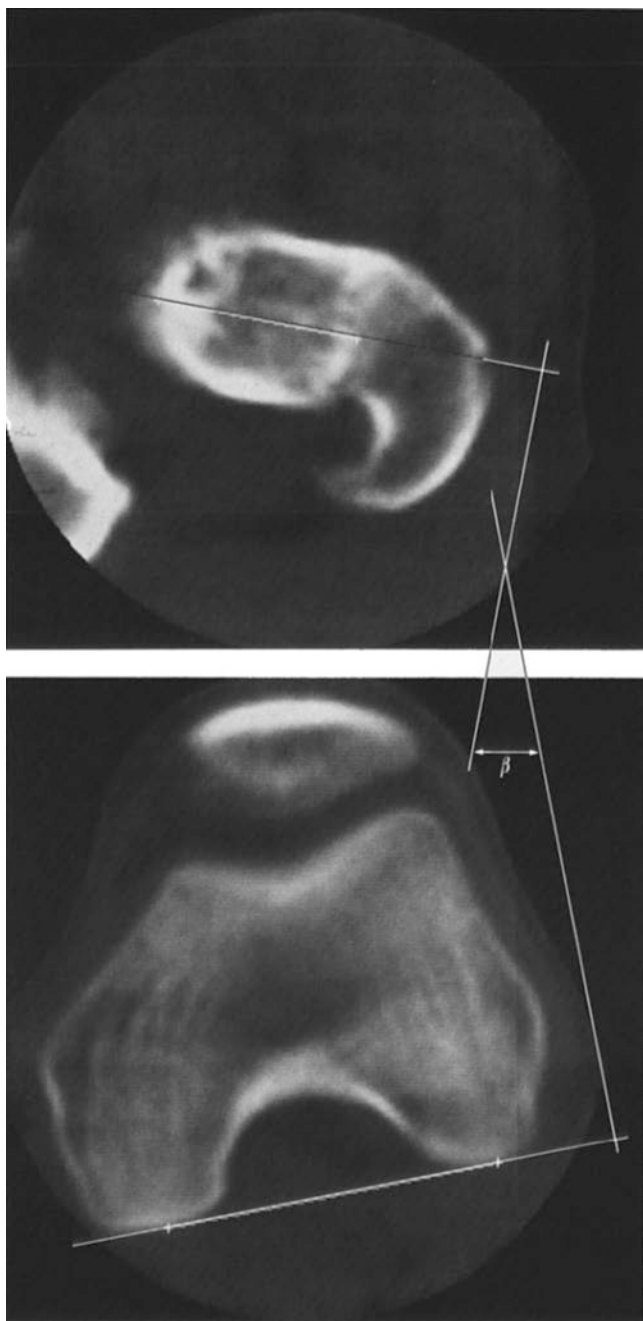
Using CT to determine rotation after IMN of femoral diaphyseal fractures by determine an angle between a line drawn tangential to the femoral condyles and a line drawn through the axis of the femoral neck. Values should be within 15° of the contralateral side (*Fig. 6.41a & 5.41b on page 172 of Jeanmart, L, AL Baert, and A Wackenheim. n.d. Computer Tomography of Neck, Chest, Spine, and Limbs. Atlas of Pathological Computer Tomography. Vol. 3. Berlin, Heidelberg, New York: Springer*)
